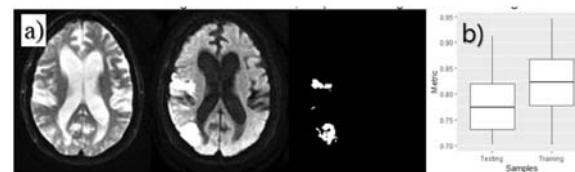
a) Diffusion MRI [b0, b1000, segmented ischemic regions] and b) model performance in training/testing using Dice similarity coefficient.
